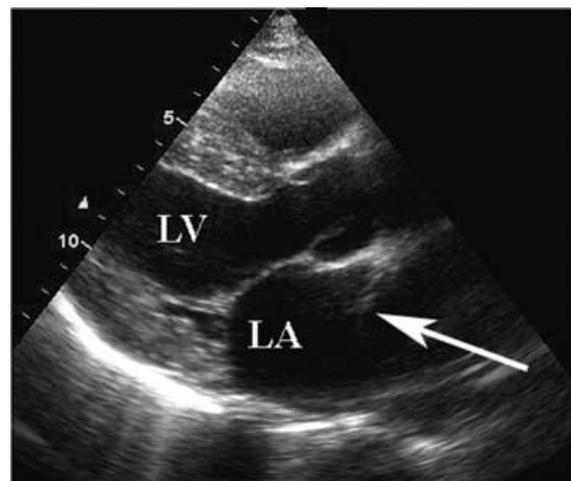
Parasternal long-axis image suggested a large sized left atrium (LA), but there was a suggestion of a “membrane” within its cavity (arrow). LV = left ventricle.
